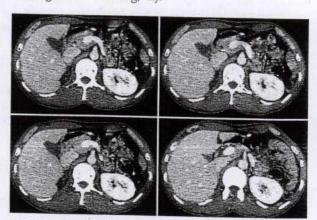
CT sections through the abdomen reveal normal size head, neck and the uncinate process of the pancreas with absent pancreatic body and tail
